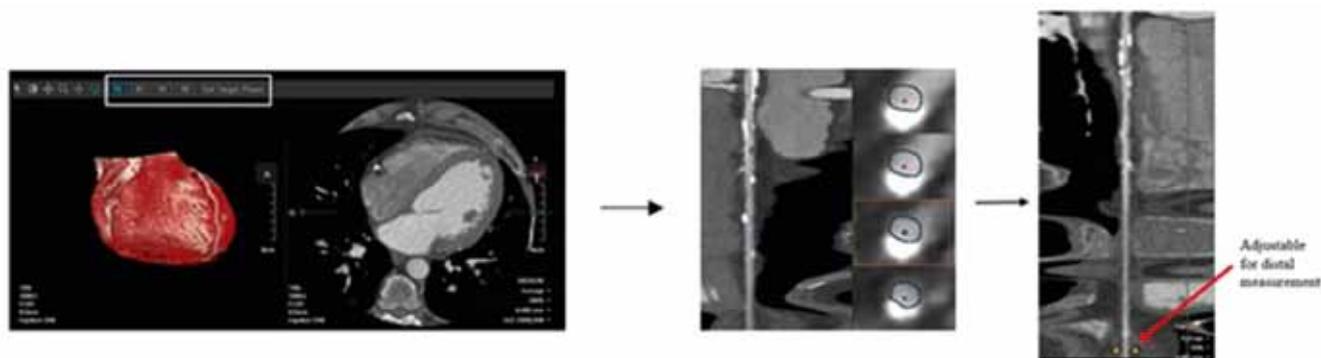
CT-FFR research software utilized for this research, patient data. Viewing imported images from 70-99% R-R and selecting the phase with the least amount of motion as the target phase (left image). Generation of centerline and contours (middle image). CT-FFR measurement with user control for distal measurement location indicated (right image).
